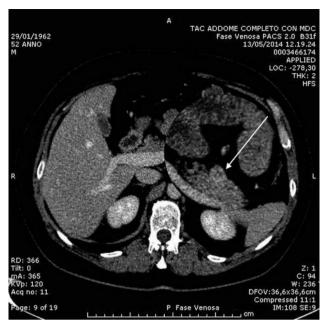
Venus phase of computed tomography (CT) scan. The arrow shows a hypervascular mass in the pancreatic body.
